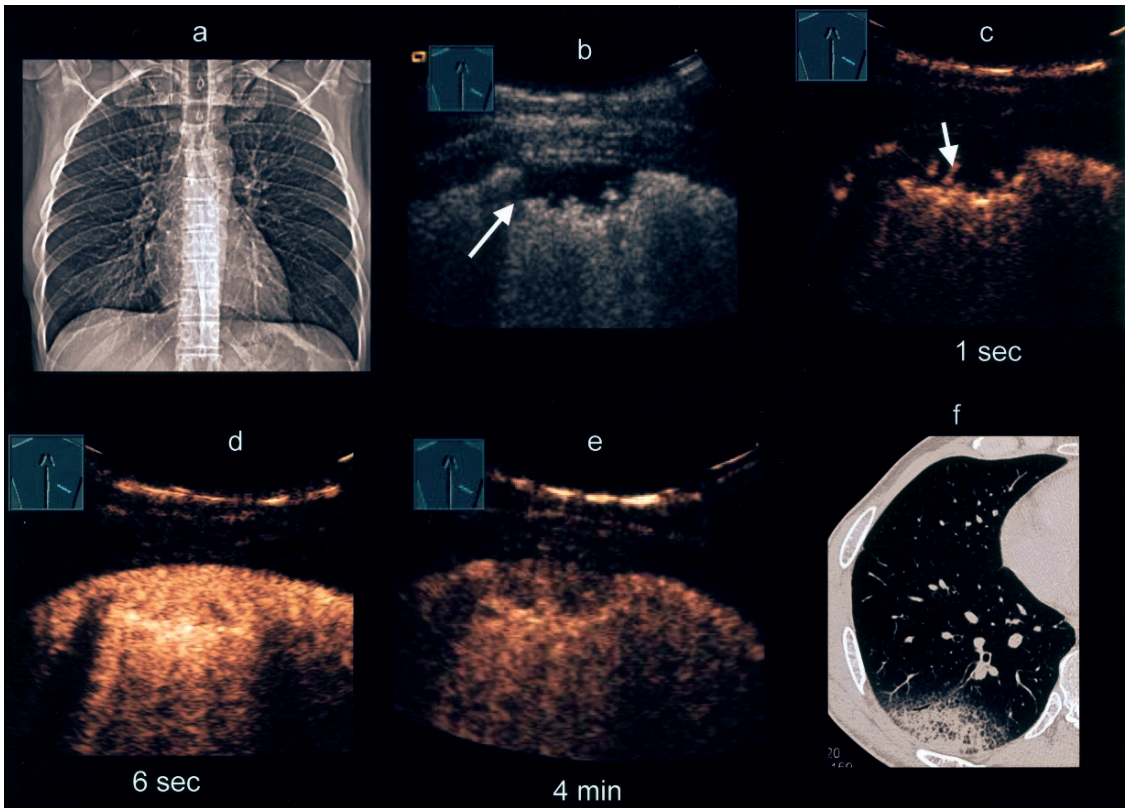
Thirty-seven year old male patient with breath-dependent right sided pleural pain. Clinical diagnosis of pleurisy was made. A: X-ray of the chest shows no pleural effusion or signs of pleuropneumonia. B: B-mode sonography shows a 2×1 cm size irregular delineated hypoechoic pleural lesion (arrow). C: Contrast enhanced sonography shows a short time to enhancement after 1 s (arrow) suggesting pulmonary arterial supply. D: After 6 s a homogeneous enhancement of the lesion is seen. E: After 4 min the lesions shows reduced enhancement. F: Computed tomography confirms diagnosis of pleuropneumonie
